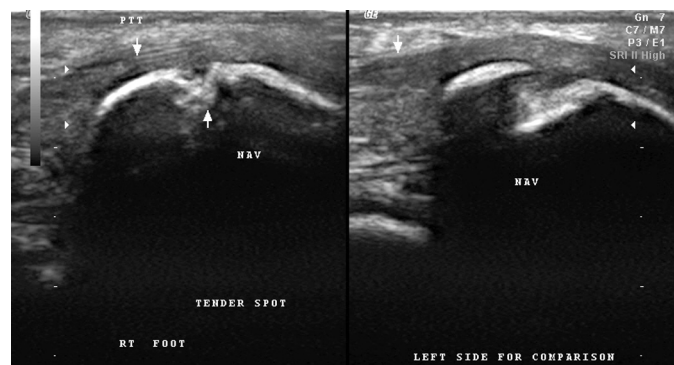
Diagnostic ultrasound results showing thickening of the right tibialis posterior tendon at the navicular insertion and irregularity of the bone at the right navicular tuberosity.
